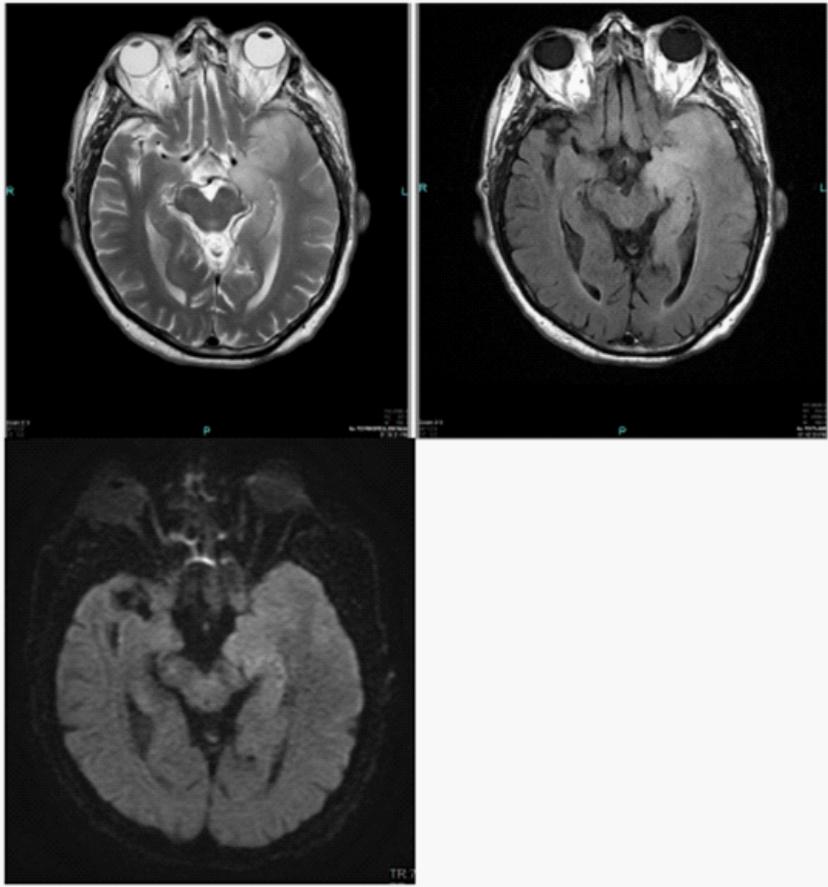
MRI. The sequences Axial T2 [A], FLAIR [B], and potentiated in diffusion (b 1000) [C] of a patient diagnosed of autoimmune non-paraneoplastic limbic encephalitis (without detecting positive antibodies) with clinical manifestations of seizures, confusion and dysphagia associated with marked cortical thickening and diffuse hyperintensity of the medial and inferior region of the left temporal lobe with extensive hippocampal commitment. In the diffusion sequence, restriction is observed in the zone.
